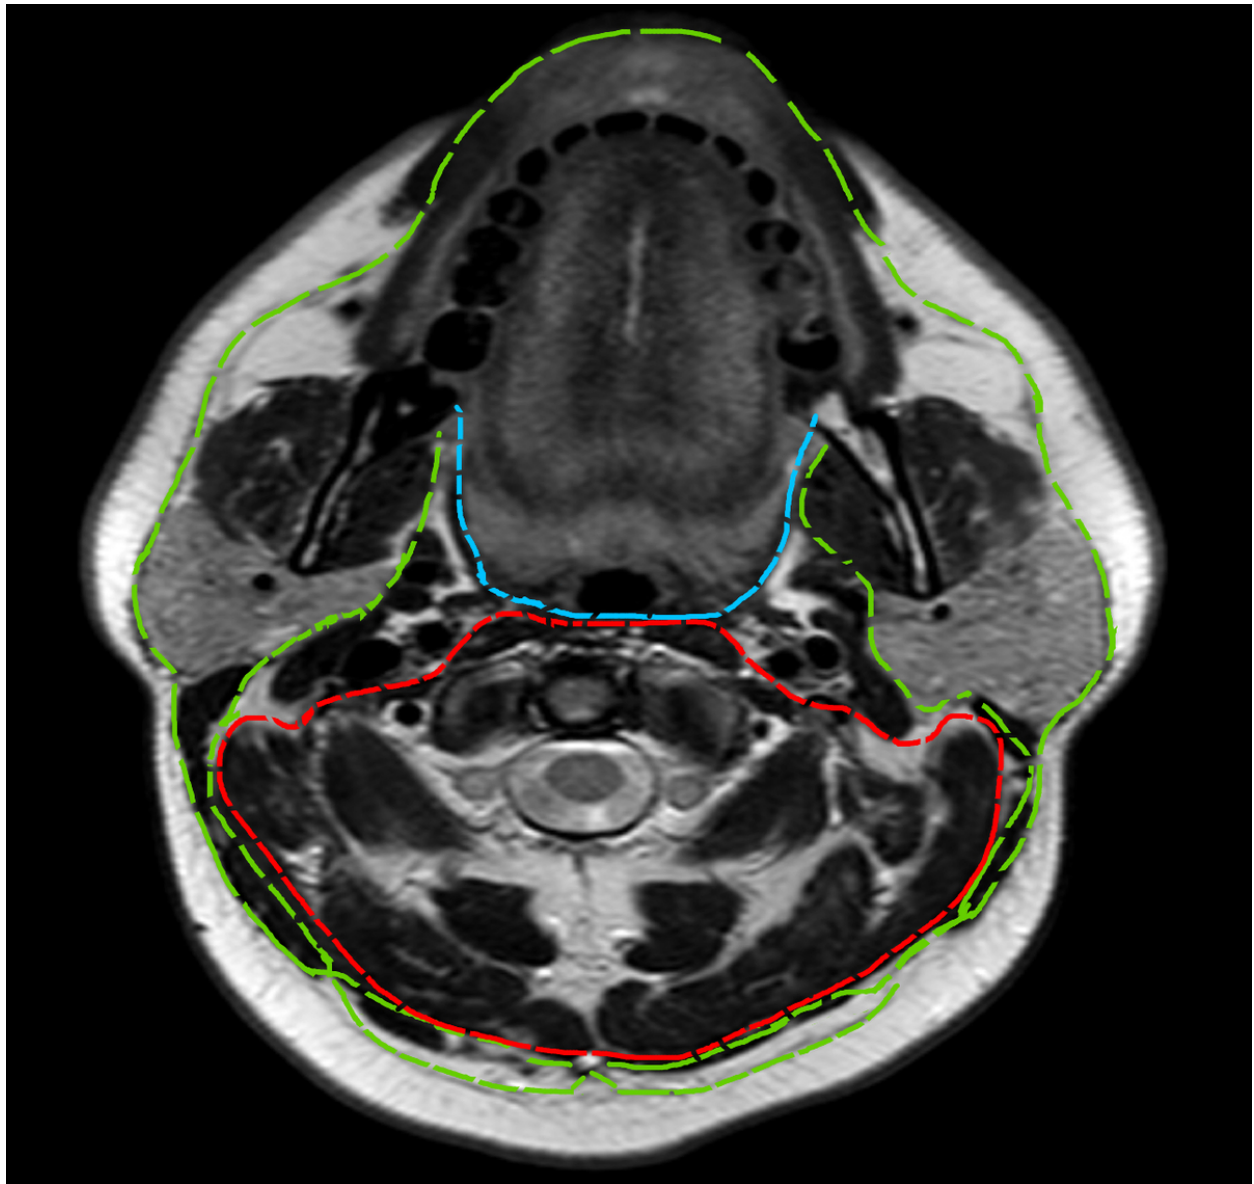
Contrast enhanced CT scan in the axial plan of the infrahyoid region demonstrating the three layers of the deep cervical fascia (superficial layer - green dash line; middle layer - blue dash line; deep layer - red dash line).
